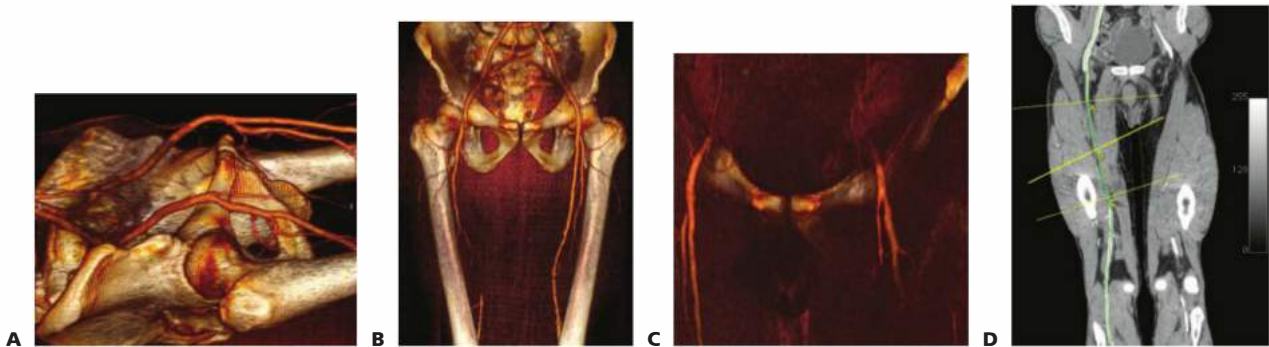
• CT angiography for infrainguinal occlusive disease. Volume rendering technique. Preoperative study of puncture zones in the CFA in a patient with a long right SFA occlusion. A. Evaluation of iliac artery inflow. B. Long right SFA occlusion with reconstitution of the above-the-knee popliteal artery. C. CT evaluation of the CFAs and femoral bifurcations prior to access. D. Centerline measurements performed to measure diameters and plan for stent graft placement in the right SFA.
